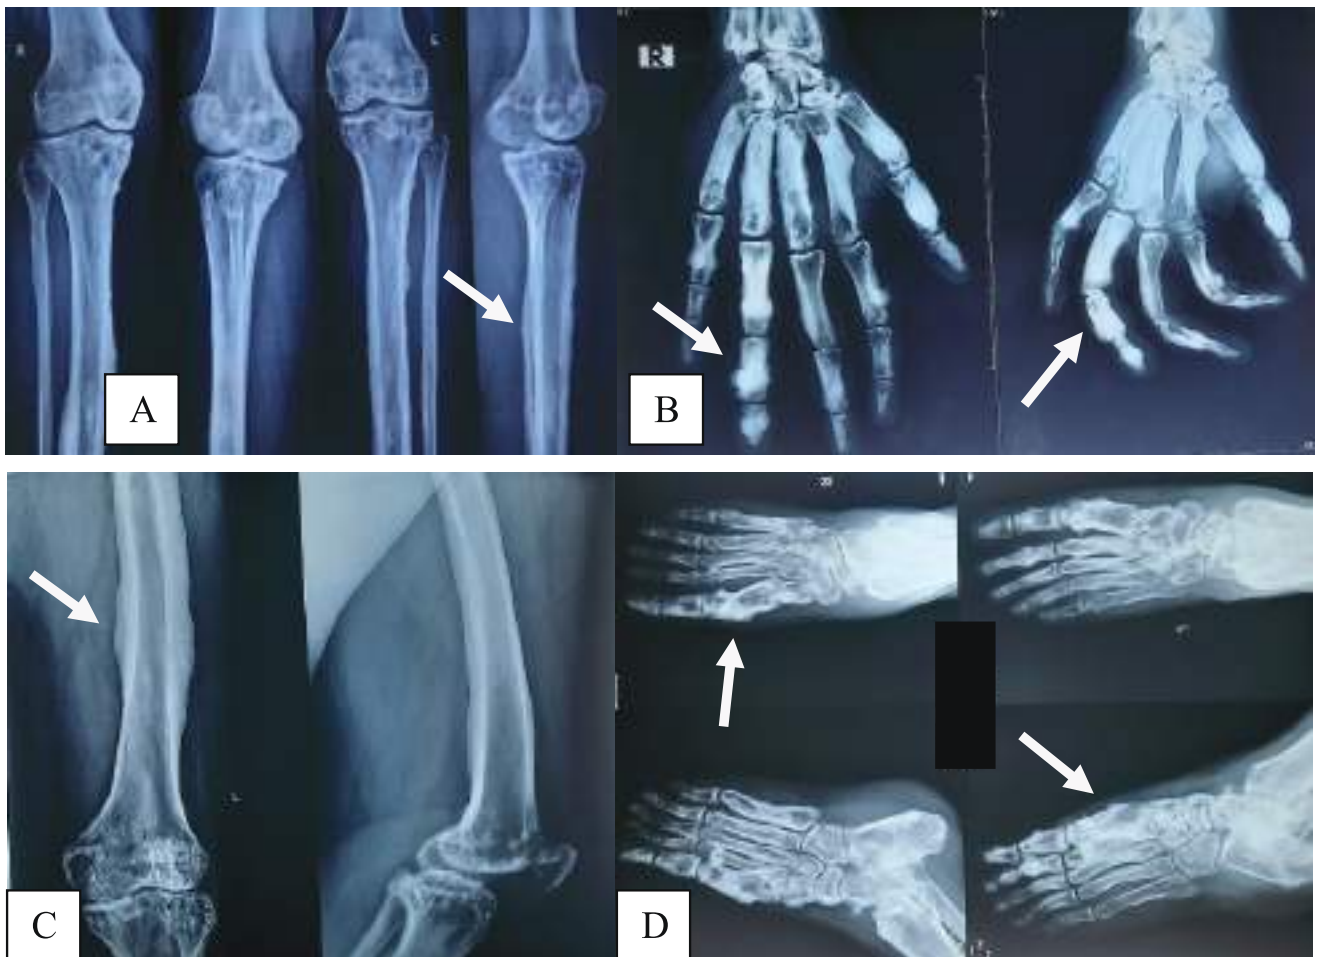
Cortical thickening showing typical dripping wax appearance in plain X-ray of long bones (A, C). Dense cortical and extra-cortical bone formation is also seen in right hand and left foot (B, D).
